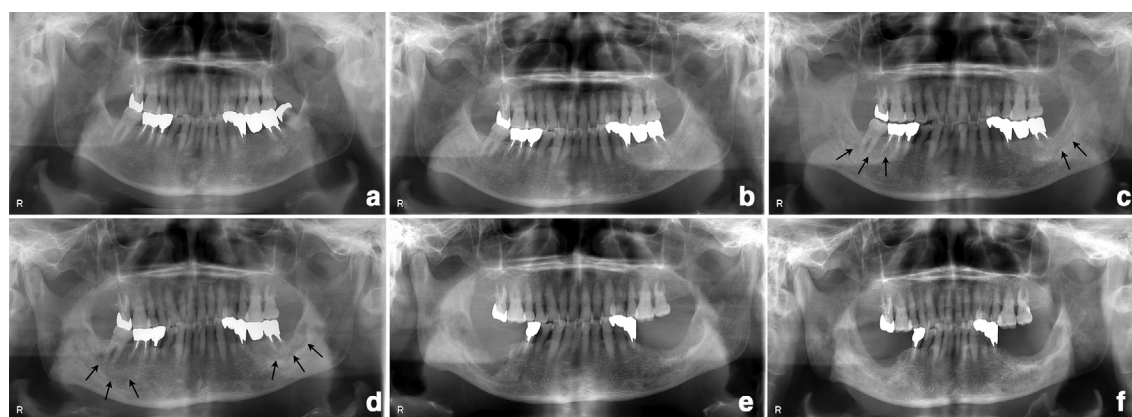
A series of panoramic images of a 68-year-old male MRONJ patient previously prescribed denosumab with a history of lung cancer and developed multiple bone metastases. Sequential panoramic images show: (A) Prior to denosumab administration. (B) Clinical bone exposure on both the left and right posterior mandible after nine months on denosumab without noticeable changes on panoramic radiographs. (C) Posterior mandibular ONJ-related radiolucent lesion seven months after denosumab cessation (arrows). (D) thirteen months after drug cessation showing more evident lesions at the same site (arrows) (E) one month after a surgical bone removal (one year and six months after drug cessation) (F) nine months after surgery. MRONJ, medication-related osteonecrosis of the jaw.
